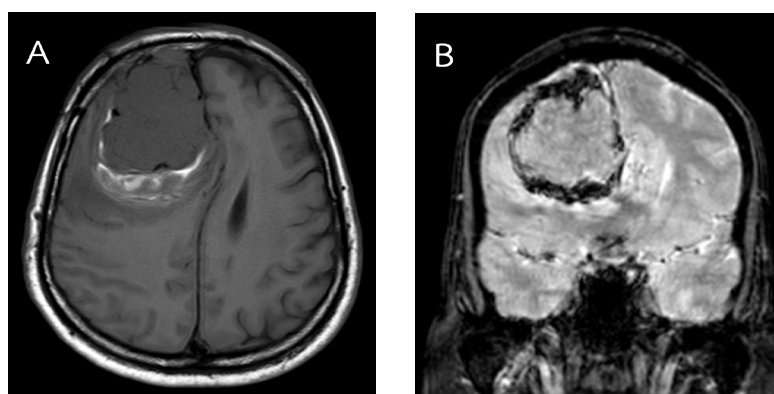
Axial T1-weighted (A) and coronal T2*GRE (B) magnetic resonance images of a grade 2 meningioma showing hemorrhagic component seen as a high signal intensity on T1-weighted image with blooming artifacts on T2*GRE
